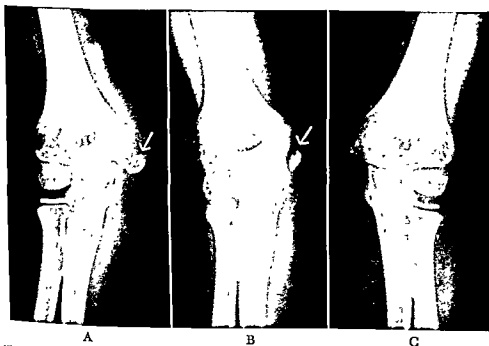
Avulsion fracture of the medial epicondyle of the humerus in a child with slight displacement treated by a long arm cast with the elbow in 90 degrees of flexion A, Anteroposterior x-ray film showing original condition. B, View of final result C, Normal arm for comparative purposes.
